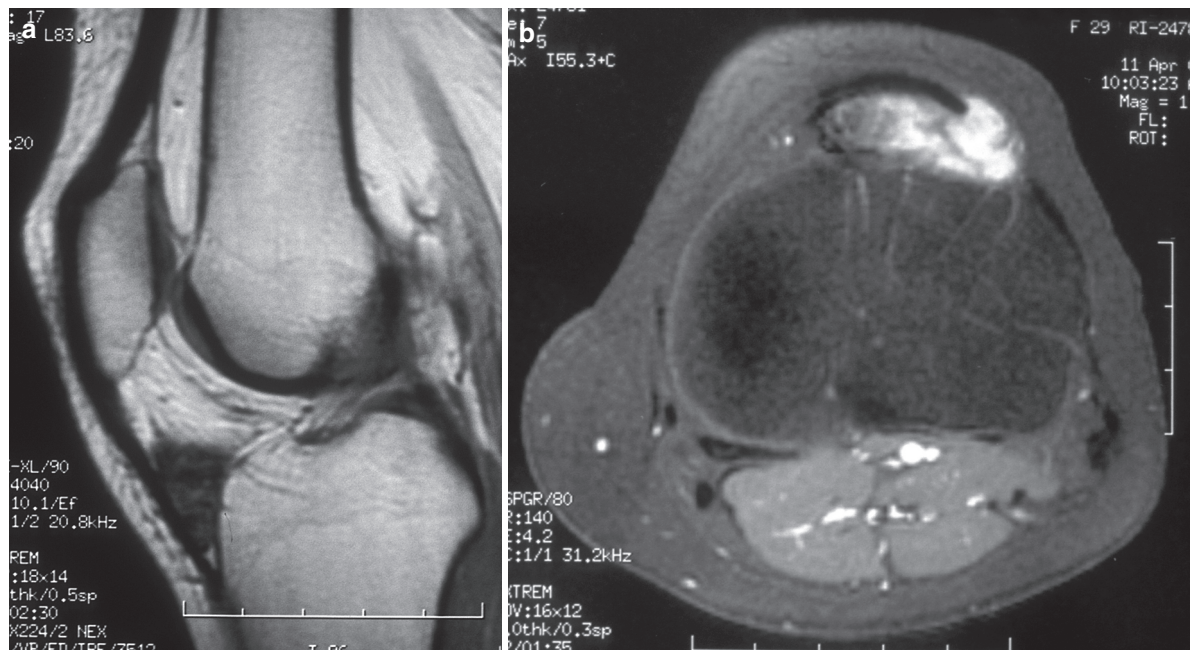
Localized pigmented villonodular synovitis of the Hoffa's fat pad. (a) Sagittal FSE T1W MR image. Hypointense lesion in the Hoffa's Fat Pad. (b) Axial GrE T1W + gd-DTPA. Heterogeneous enhancement lesion in the Hoffa's Fat Pad
